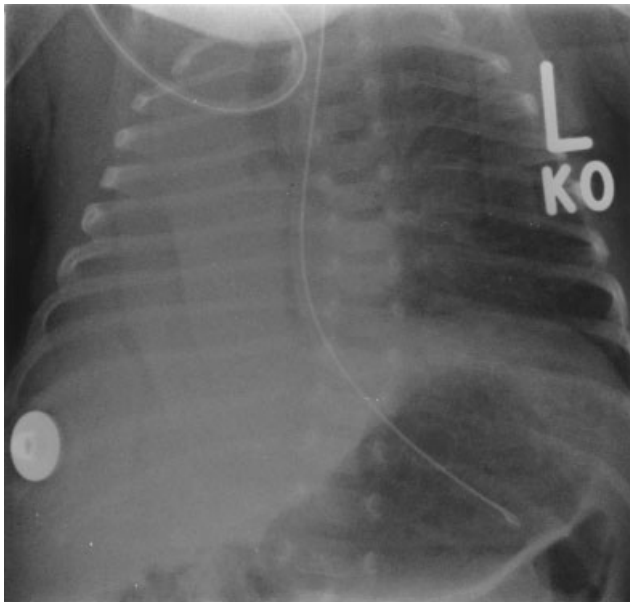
Chest X-ray of case 3 shows complete collapse of right lung. Air bronchogram shows abrupt cutoff of right main bronchus, indicating site of polyp. Remaining vertical translucent stripes projecting over right hemithorax represent skin folds.
